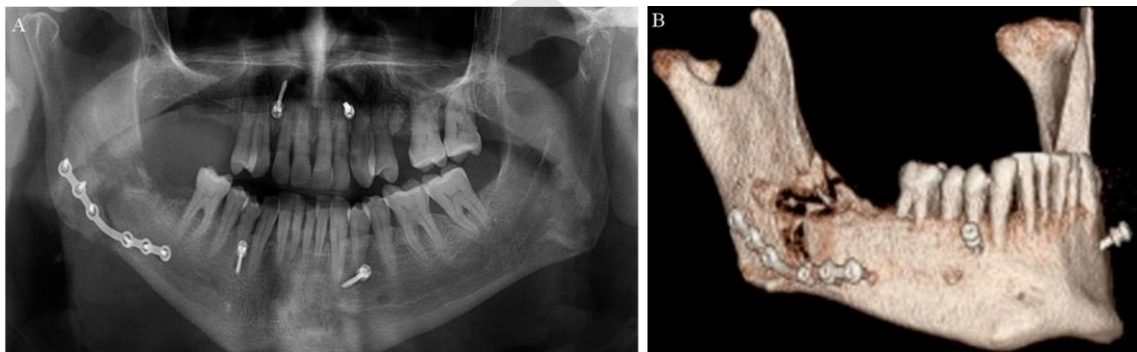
A control panoramic radiograph performed 2 weeks after surgery (A).
